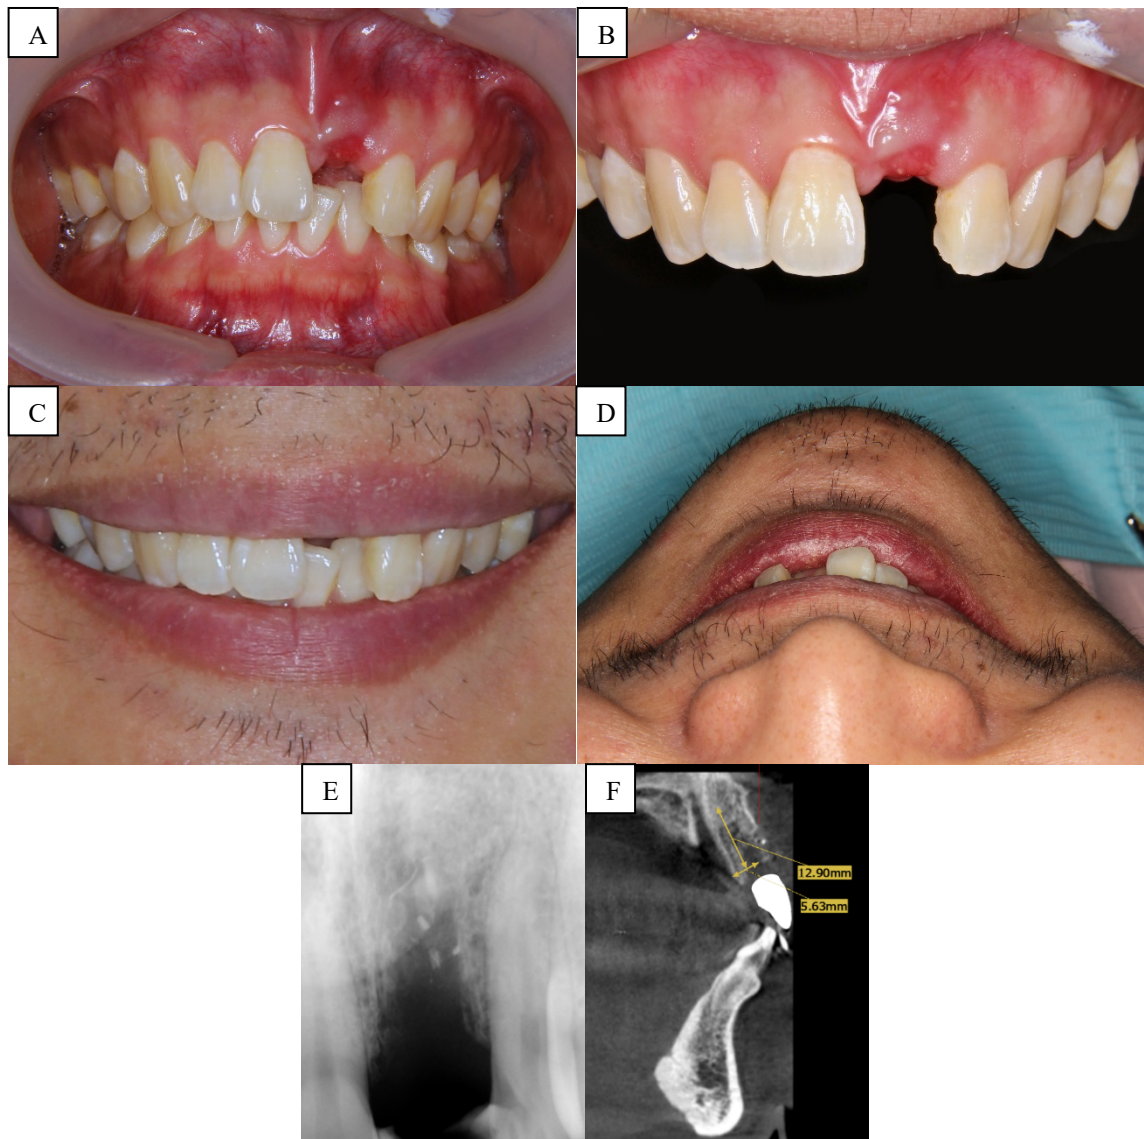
Pre-operative assessment 4-weeks post-extraction of 21. A) frontal view B) Area of complaint C) Smile view D) 12 O'clock smile view E) An IOPA radiograph showed the healing socket area of extracted tooth 21 F) CBCT analysis with radiographic guide measuring the bone quality and quantity.
